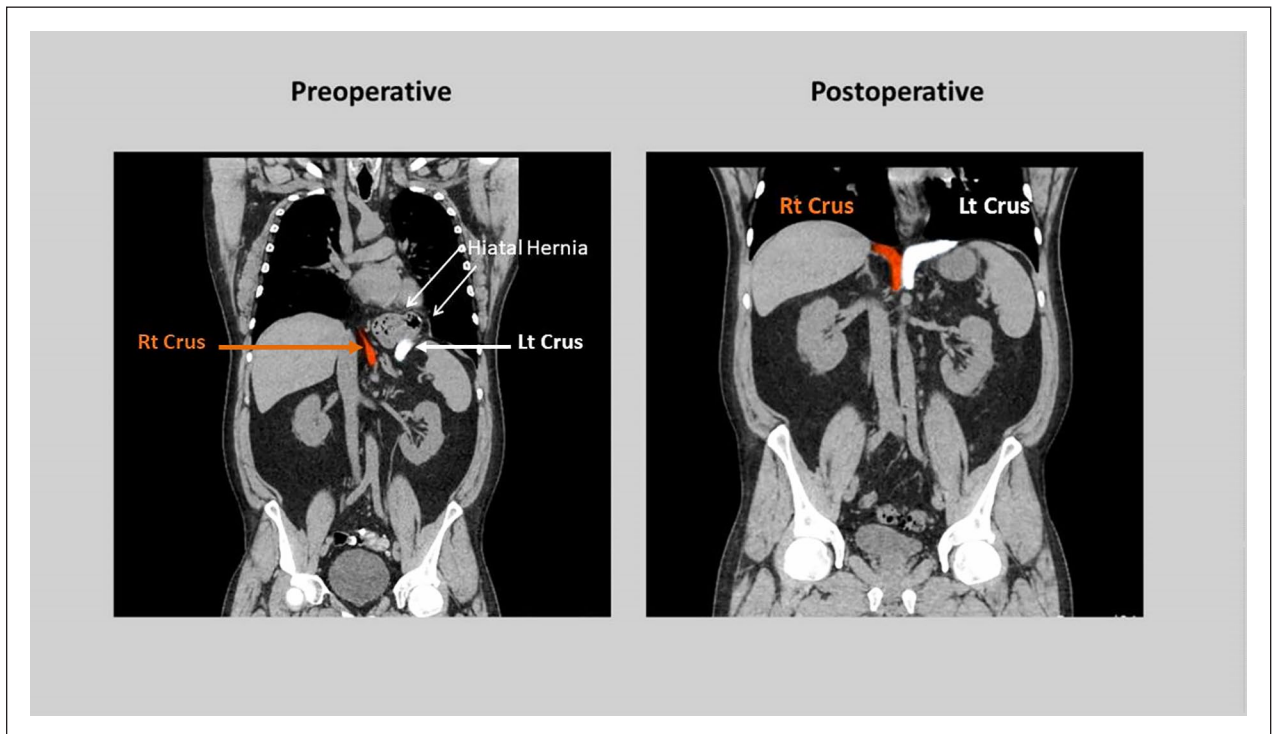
Preoperative and postoperative coronal CT images demonstrating apposition of both crura.
